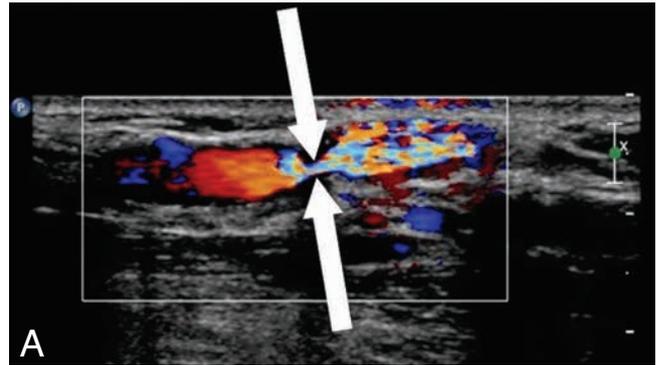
Color Doppler at the level of the anastomosis between the post-anastomotic radial artery and the radial vein (A) reveals a tight stenosis (arrows).
